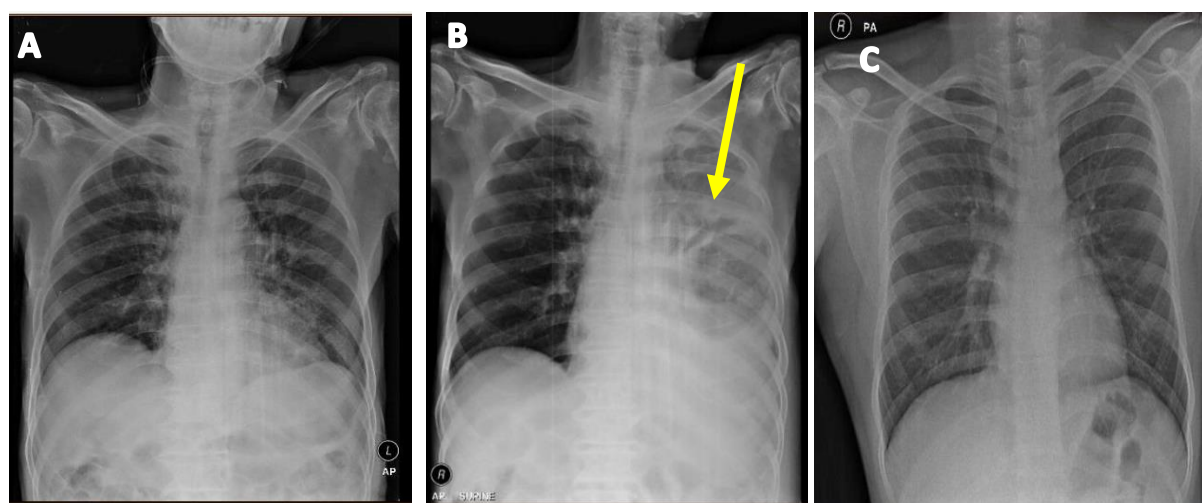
Chest X-ray comparison: (a) Chest X-ray on admission (b) Chest X-Ray on 7th day of hospital stay showing more infiltrate than chest X-ray on admission (yellow arrow) (c) A week after being discharged
